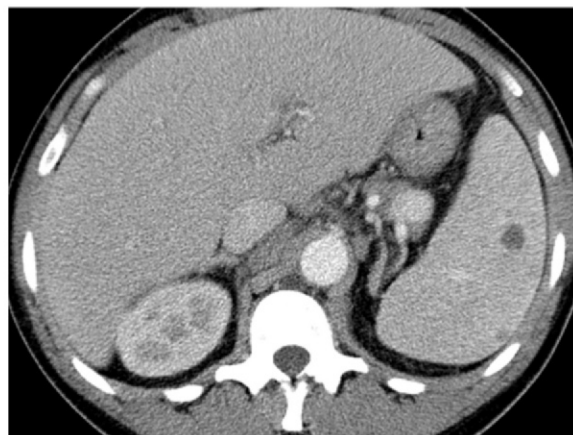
Hodgkin lymphoma in a 46-year-old man with HIV infection who presented with recurrent fever, chills, generalized body aches, cough, loose stools, axillary lymphadenopathy, and pancytopenia. He had been receiving ART for 4 months, during which time his CD4 count increased from 43 cells/ μL (nadir) to 144 cells/ μL . (a, b) CT images show axillary (a) and mediastinal (b) lymphadenopathy. There was also hilar, mesenteric, and retroperitoneal lymphadenopathy. (c) CT image shows extranodal findings including hepatosplenomegaly and small hypoattenuating areas in the spleen. Axillary lymph node biopsy demonstrated nodular sclerosing Hodgkin lymphoma.
